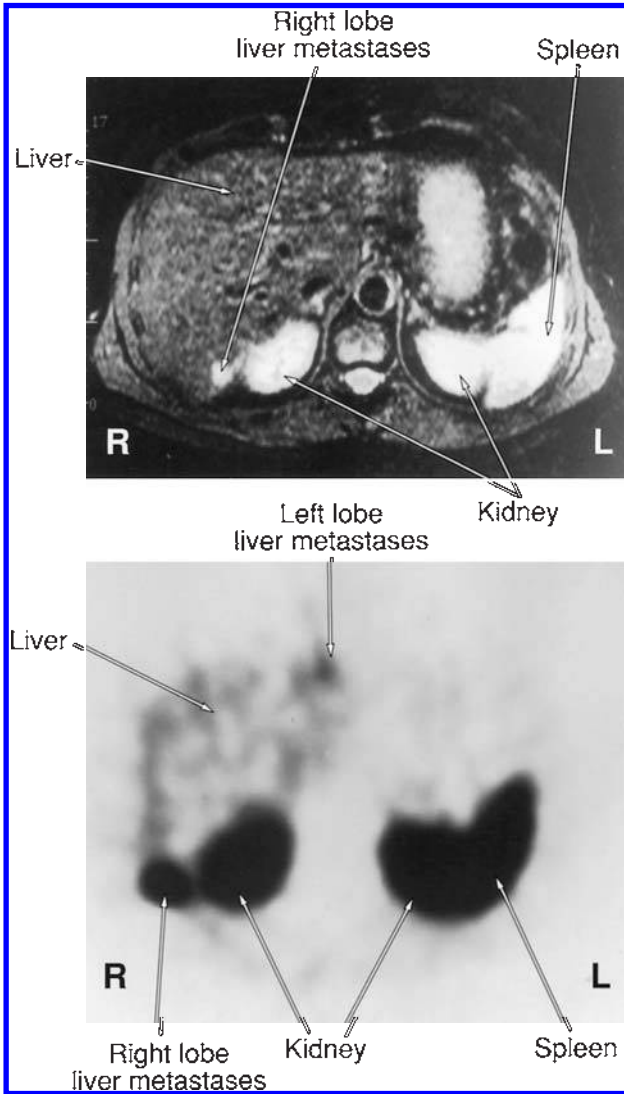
Sagittal MRI image (top) showing the high signal abnormality in the posterior aspect of the right lobe of the liver in a patient with Zollinger-Ellison syndrome, and sagittal SRS image (bottom) showing the same area in the posterior aspect of the right lobe of the liver and identifying a second otherwise occult left-lobe liver metastasis.
